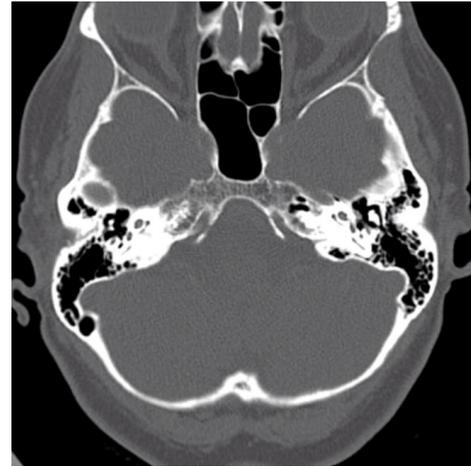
Temporal CT scan showing the left middle ear space partially occupied by a soft tissue density mass originating from the promontory (white arrow).
